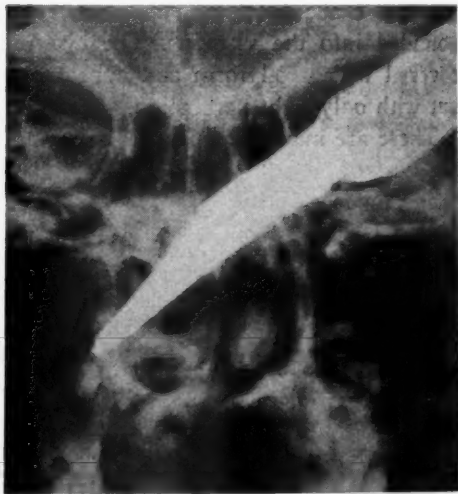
(Thomas). X-ray representation of knife in place.
